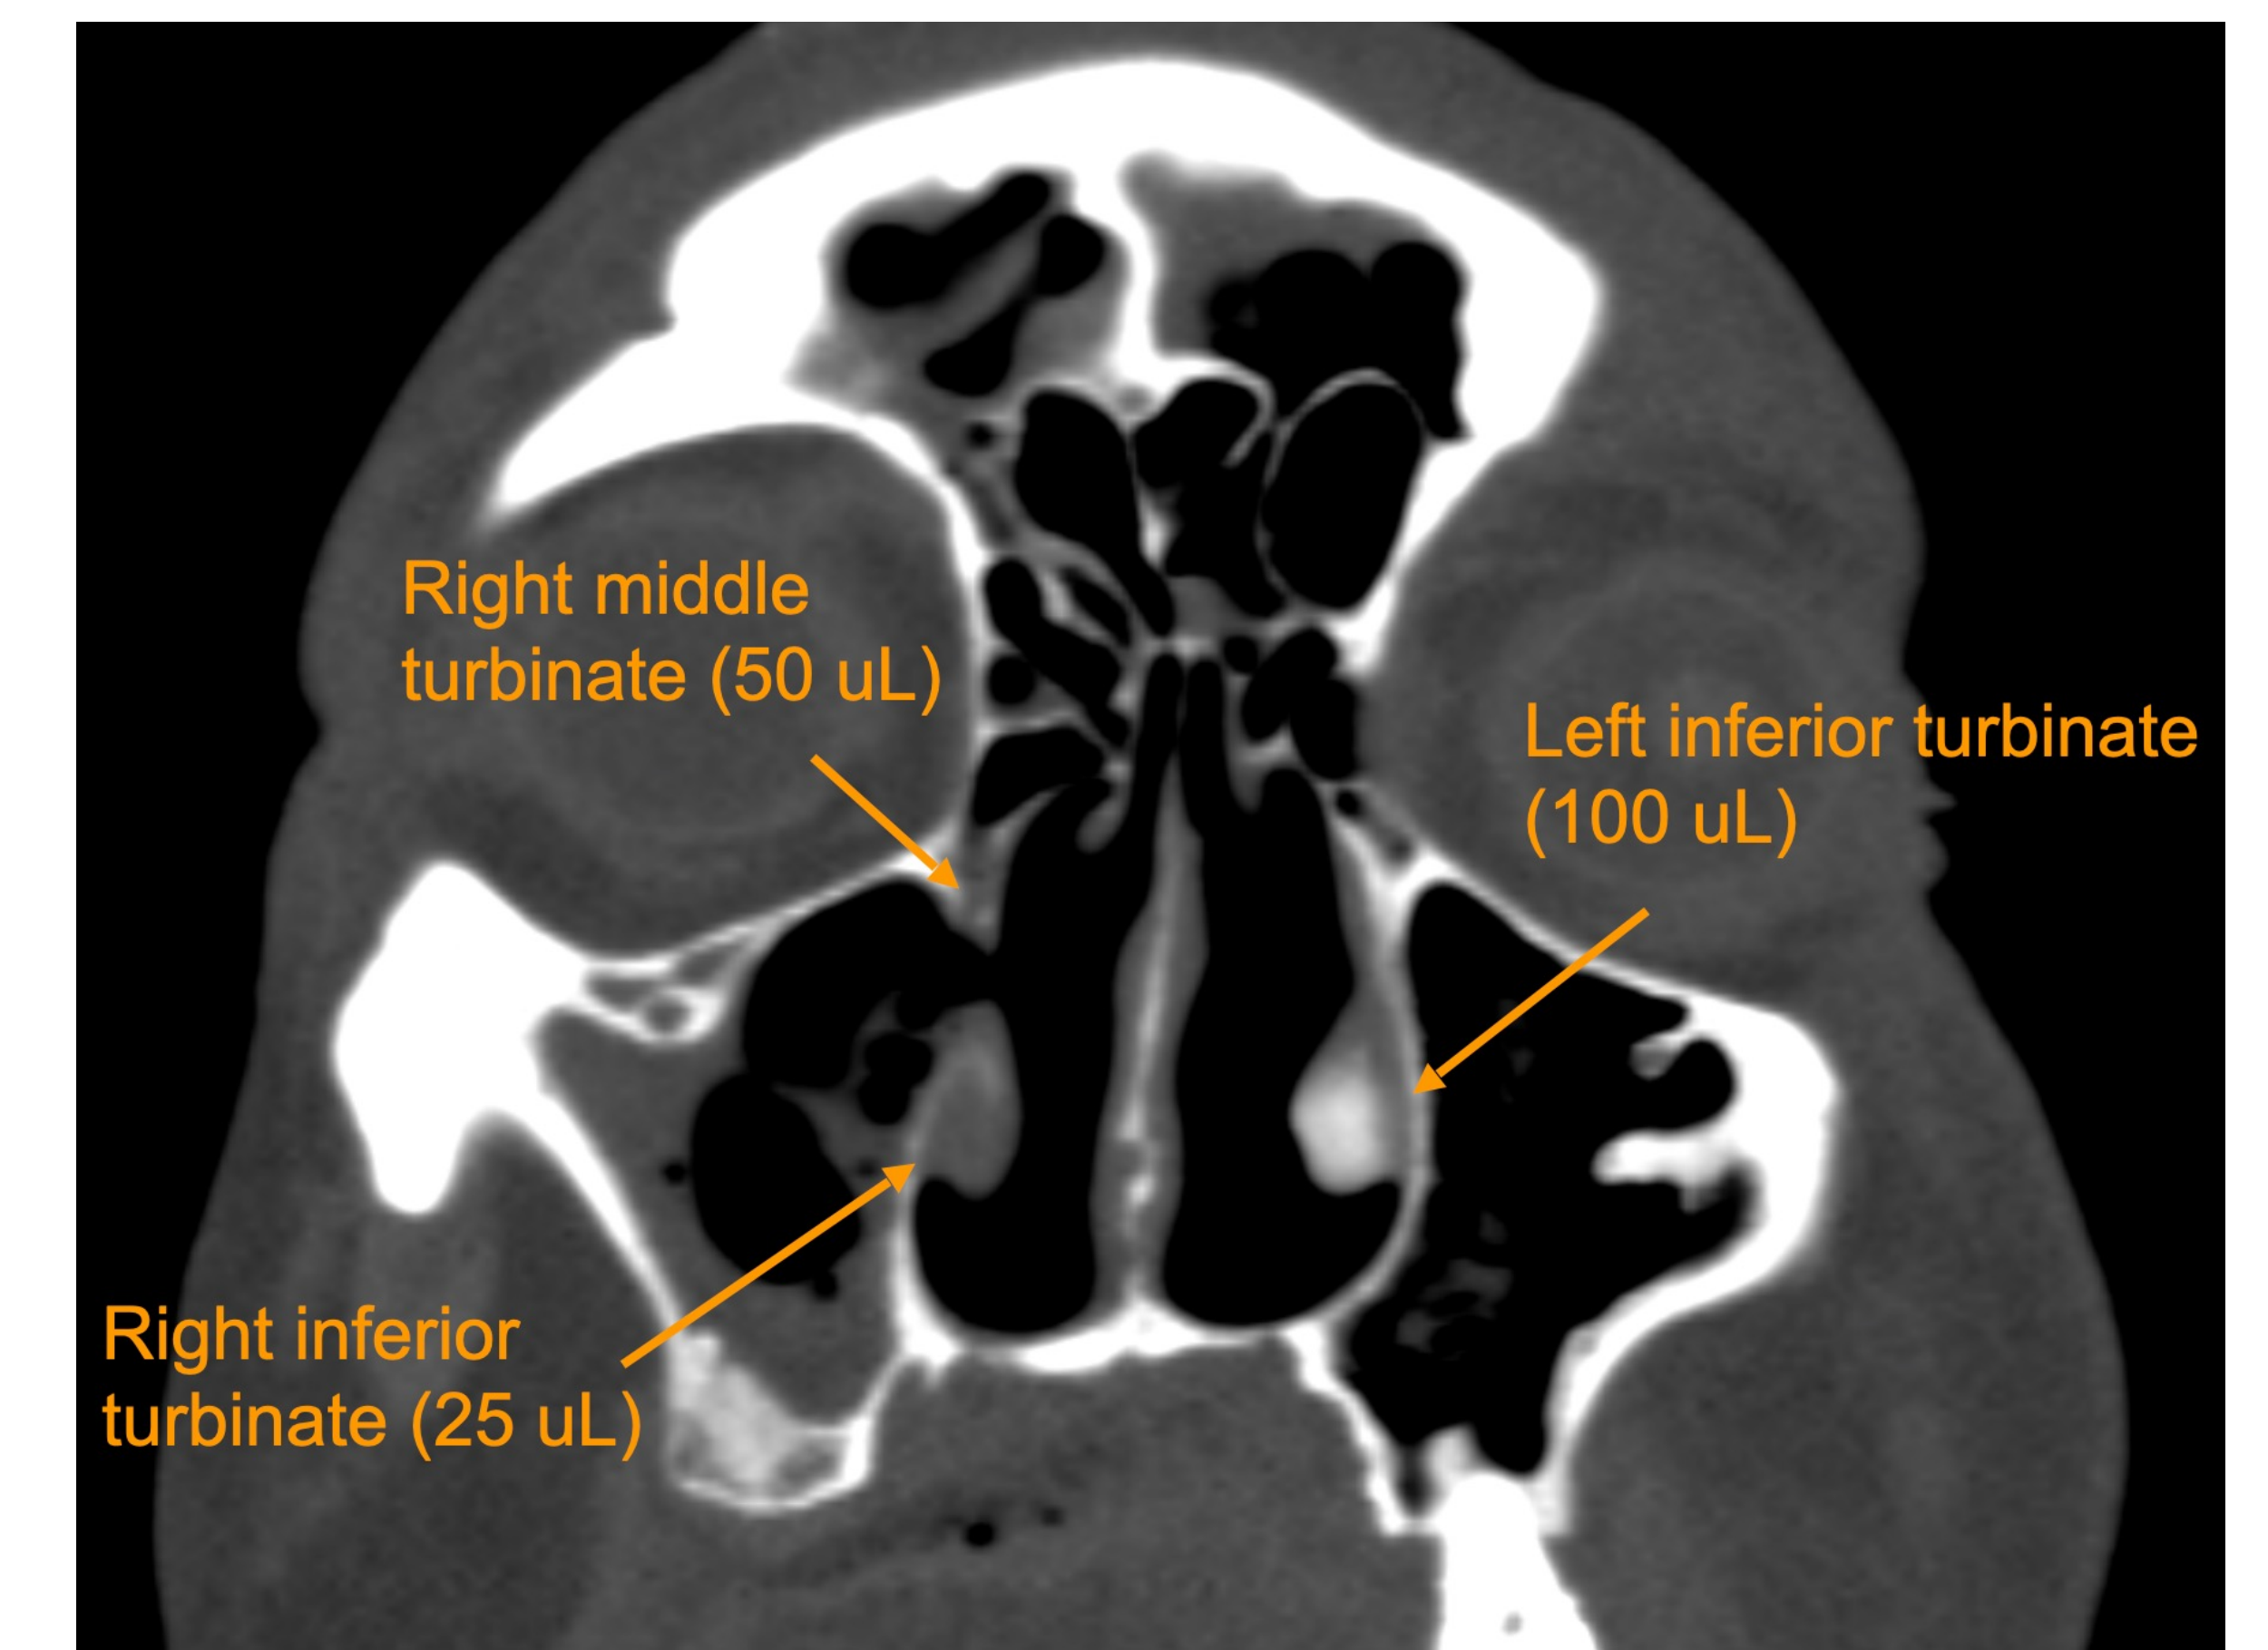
Coronal head CT bone window demonstrating volume-dependent injection contrast in the middle and inferior turbinates
